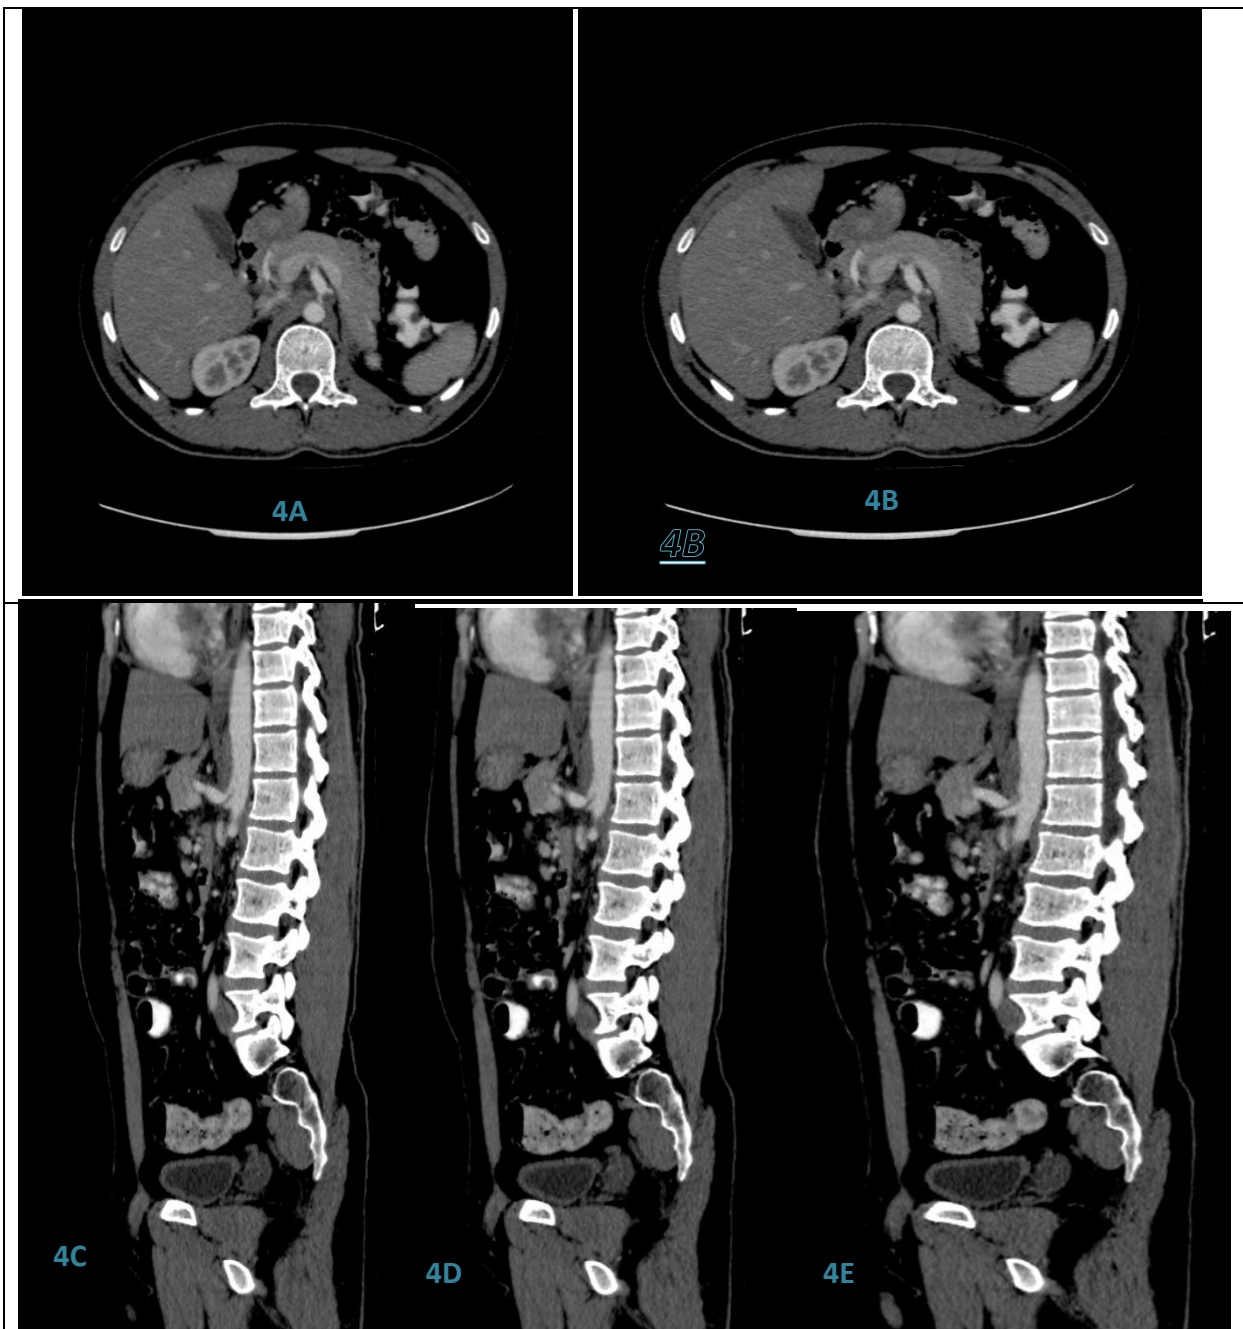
CT abdomen demonstrating the characteristic “hooked” appearance of celiac artery near its origin representing median arcuate ligament syndrome
